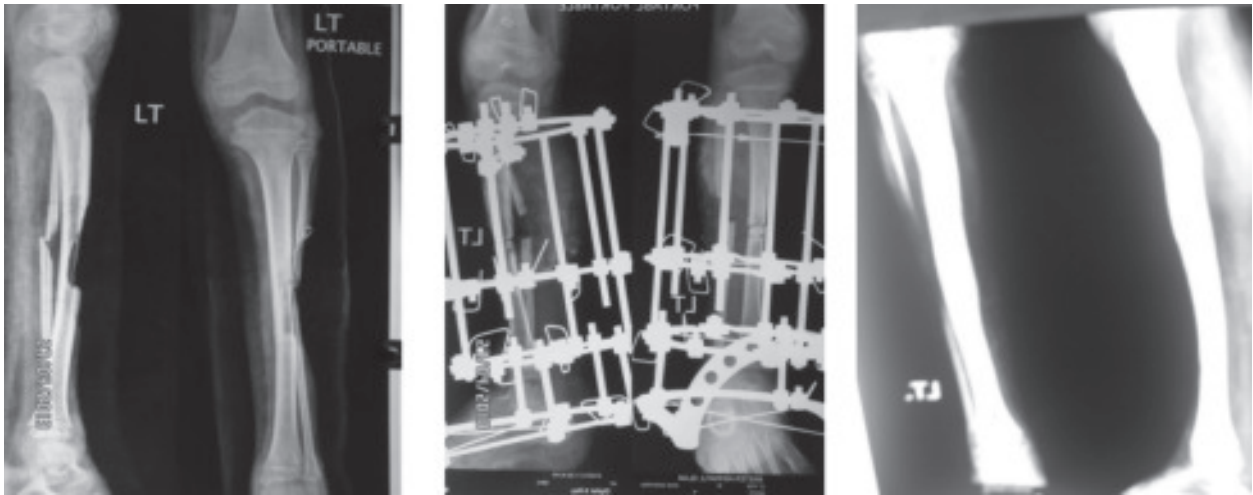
a) Initial x-ray, b) After application & c) After removal of Ilizarov fixator
